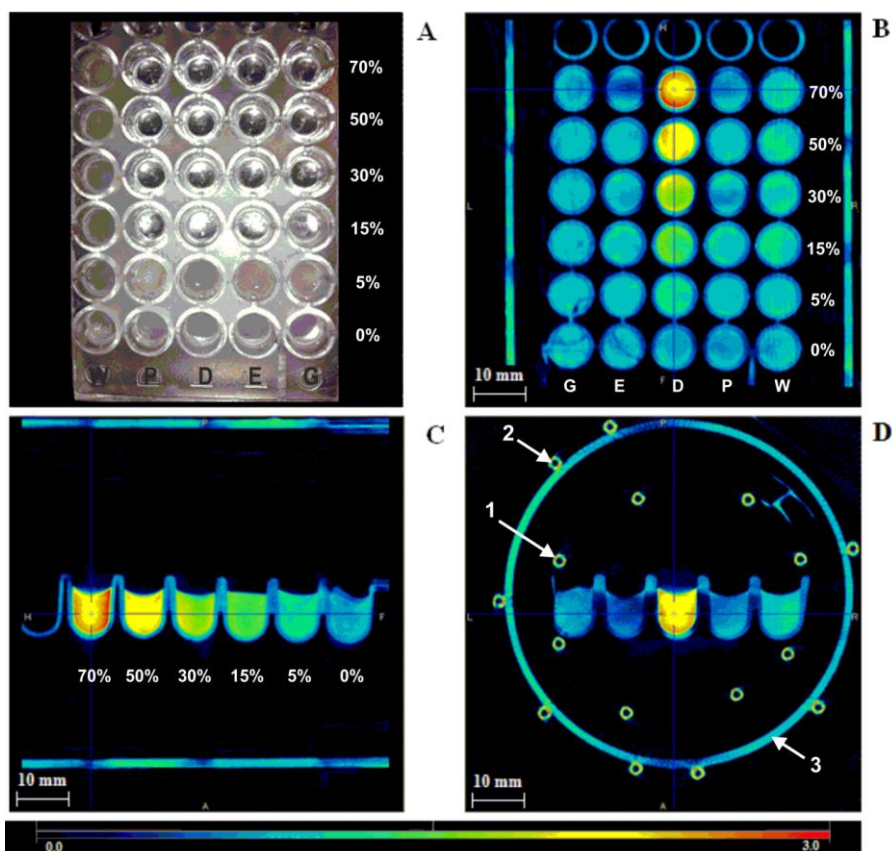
CT image of the 3 orthogonal views of different CPAs different concentrations in a 9x5-well microplate, at $-140\text{ }^{\circ}\text{C}$. The CT image uses the cold scale and a spatial resolution is $200\text{ }\mu\text{m}$. The solutions correspond to water (W), 1,2-propanediol (P), dimethyl sulfoxide (D), ethylene glycol (E) and glycerol (G)
